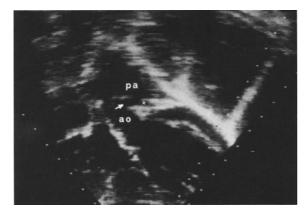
Echocardiography. Preoperative echocardiography showing the aortopulmonary window (white arrow) with anomalous origin of the left coronary artery (asterisk) from the ductus-like aortopulmonary window (*Ao* aorta, *PA* pulmonary artery) (reproduced with permission from: Corno AF, Pierli C, Biagioli B, Lisi G, Grossi A (1988) Anomalous origin of the left coronary artery from an aortopulmonary window. J Thorac Cardiovasc Surg 96:669–671)
